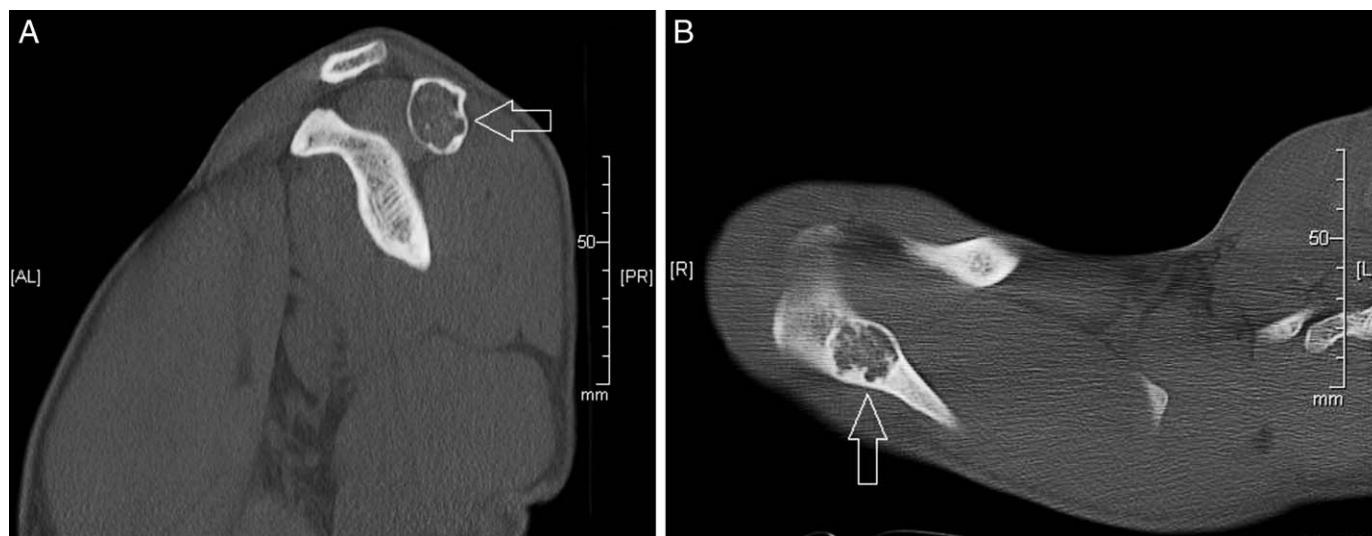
Computed tomography image of bone lesion in acromial complex. A, Coronal view. B, Axial view.
